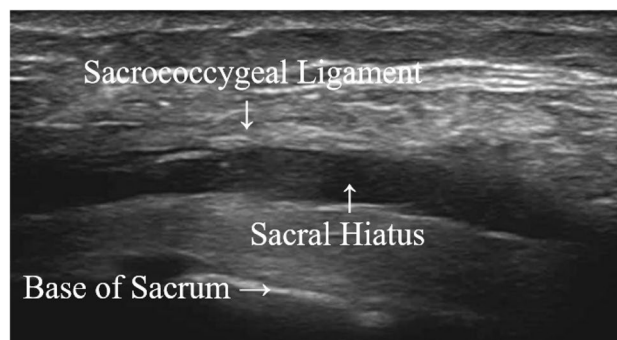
Cross-sectional ultrasound view of the Sacral
